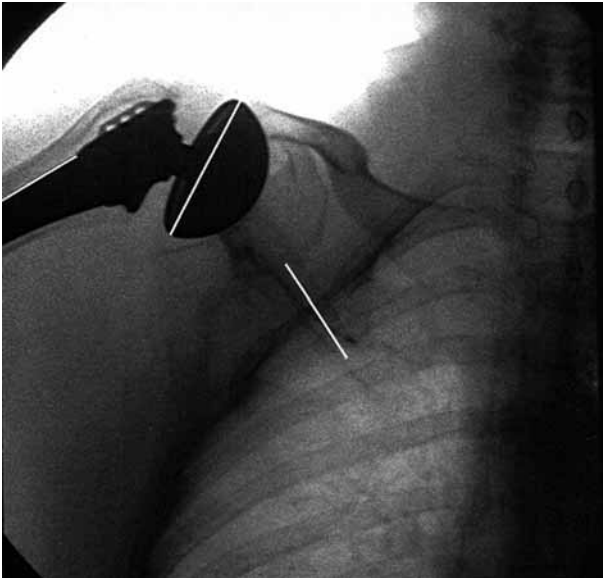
Radiograph of the shoulder in the scapular plane with the arm in full active abduction. The base of the shell, the lateral border of the stem and the scapular spine were used as landmarks.
